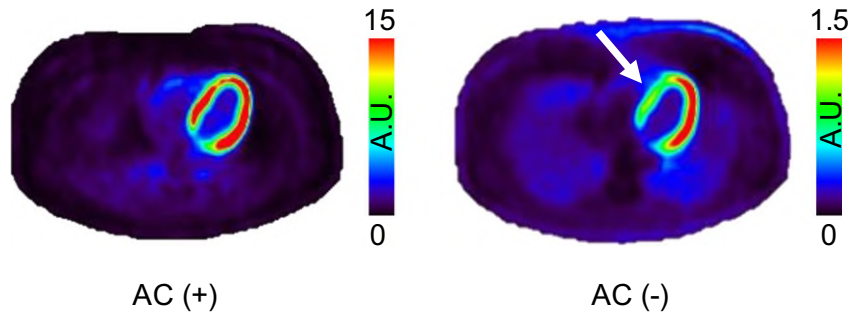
Example transaxial images of human ^{18}F -FDG PET at the mid-ventricular level with and without attenuation correction (AC). False-positive uptake defect is seen in the septal wall without attenuation correction (white arrow).
